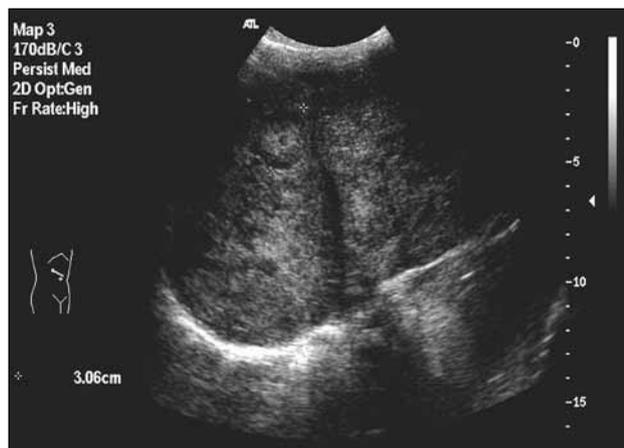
Ultrasonography of the liver showing multiple target-like lesions.
